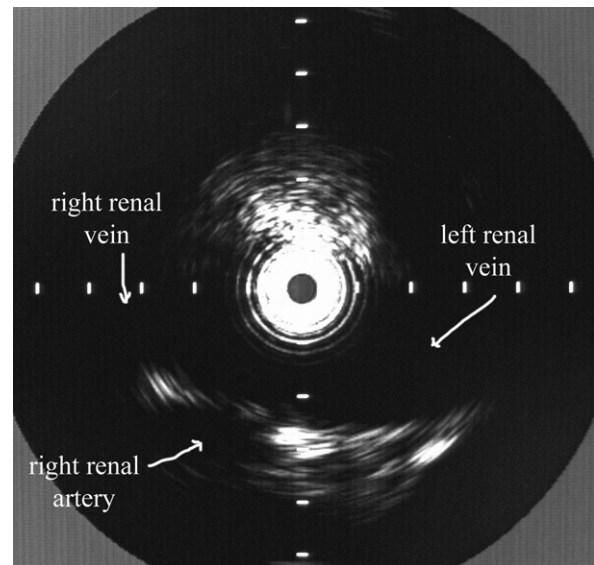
An intravascular ultrasound image at the same level in the inferior vena cava as Fig 1 shows the decreased ultrasound penetration from the shadowing effect of the sheath and its radiopaque tip. This demonstrates that the sheath is in the desired position in the inferior vena cava for accurate delivery of the filter.
